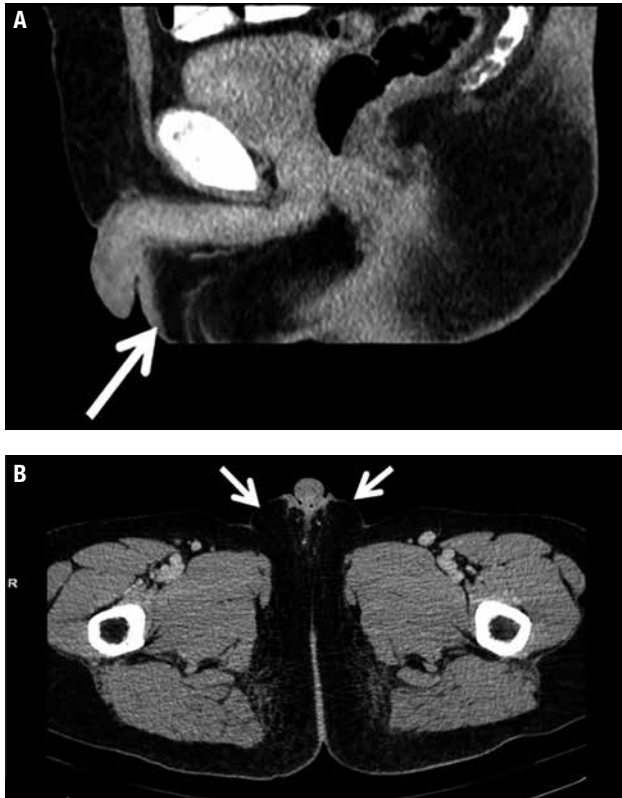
Computed tomography: bilateral absence of testes within the scrotum (arrow). (A) Sagittal plan. (B) Transversal plan.
